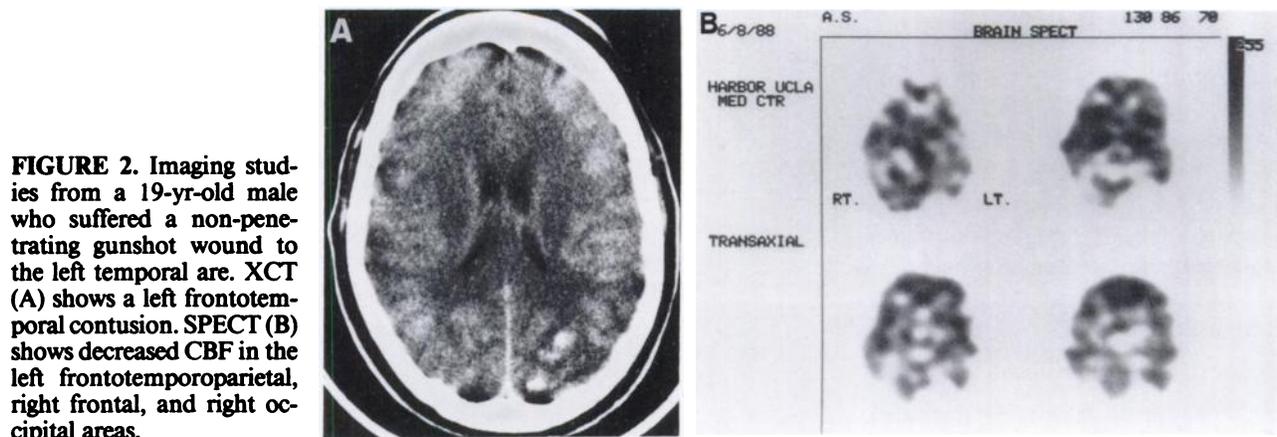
Imaging studies from a 19-yr-old male who suffered a non-penetrating gunshot wound to the left temporal area. XCT (A) shows a left frontotemporal contusion. SPECT (B) shows decreased CBF in the left frontotemporoparietal, right frontal, and right occipital areas.
